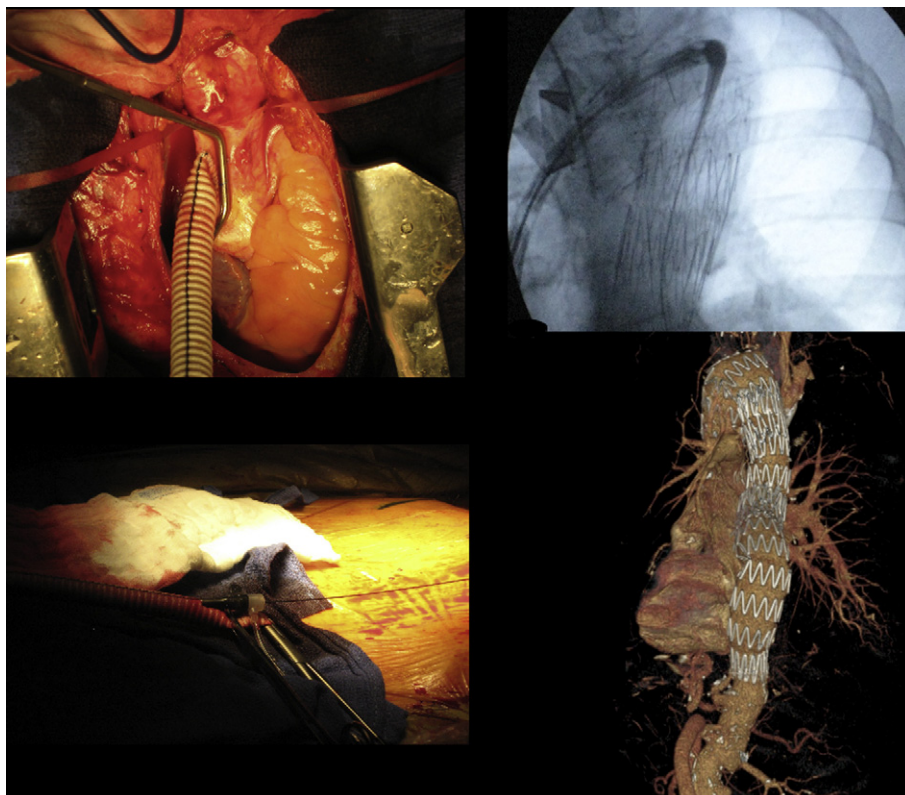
Peroperative view and postoperative CT scan reconstruction.
